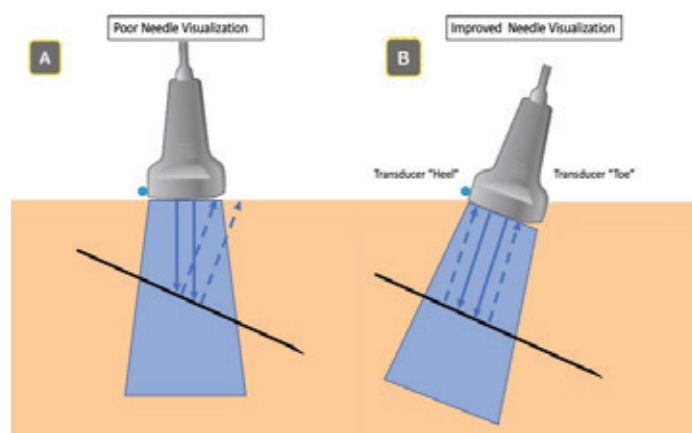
Low angle of insonation: some ultrasound waves are reflected away from the transducer.
